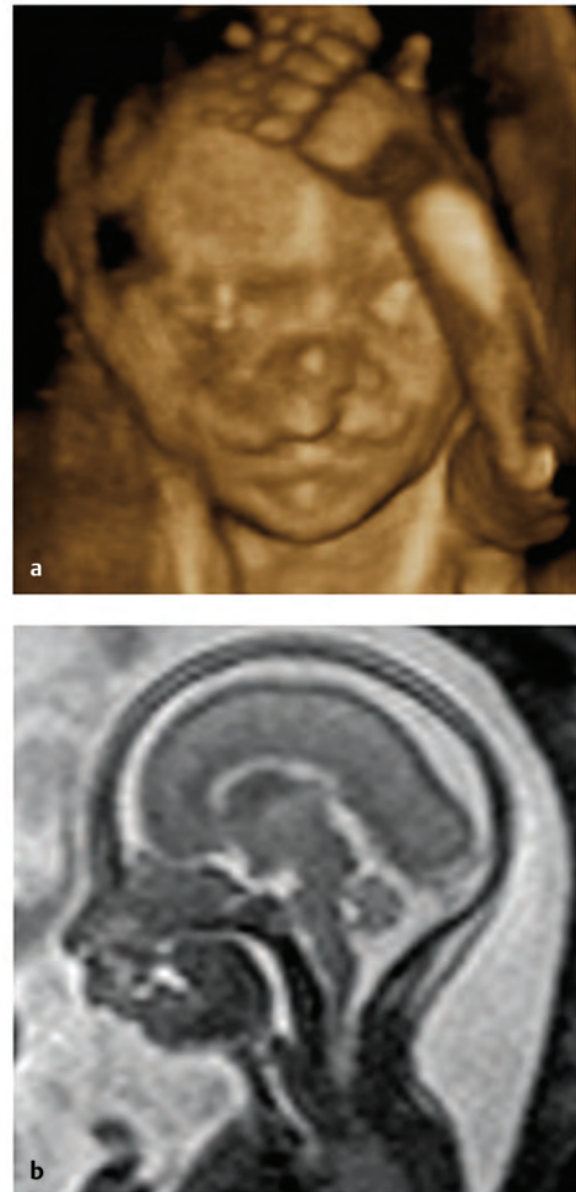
Prenatal diagnosis of cleft lip and palate. (a) Fetal three-dimensional sonography demonstrating a left unilateral incomplete cleft lip. (b) Fetal magnetic resonance image demonstrating a Veau II cleft palate. The fetal tongue rides high into the nasal cavity due to the cleft hard and soft palate.
